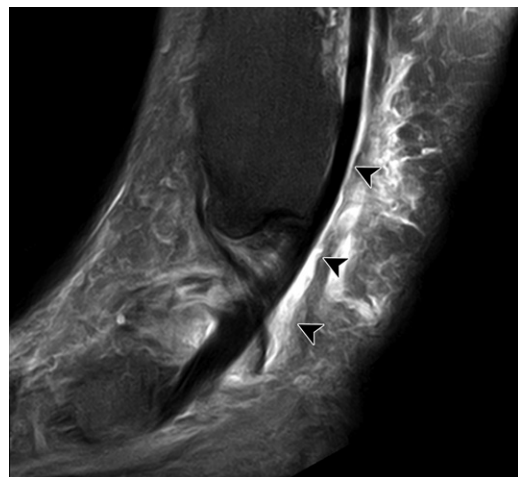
PTT tenosynovitis in a 52-year-old woman with chronic medial retromalleolar pain predominantly at night and during walking. Sagittal fat-suppressed T2-weighted MR image obtained at the medial malleolus shows the PTT outlined by excessive fluid in its tendon sheath (arrowheads) and surrounding soft-tissue inflammation.
